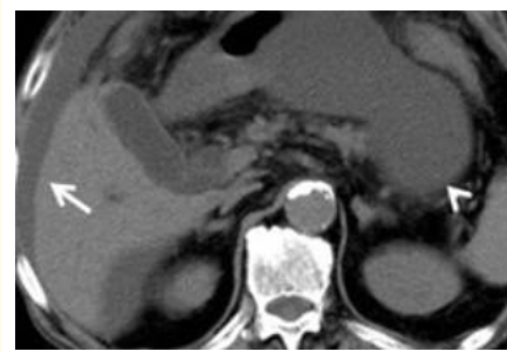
CT of abdomen and pelvis with contrast showed free fluid around the gallbladder fossa, liver and pancreas.
